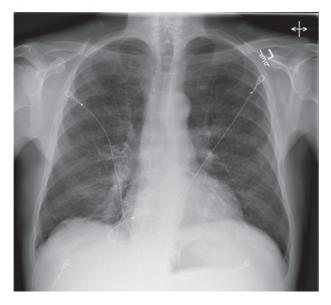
Chest X-ray on the day of admission; no significant change compared to his chest X-ray prior to his admission.
